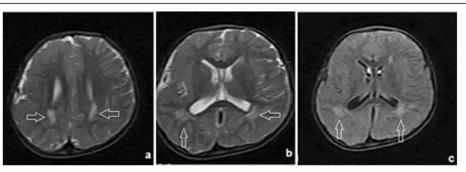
a-c MRI brain demonstrates ADEM 1 pattern, axial FLAIR Wi showing small hyperintense fronto-parietal periventricular lesions (arrows)
